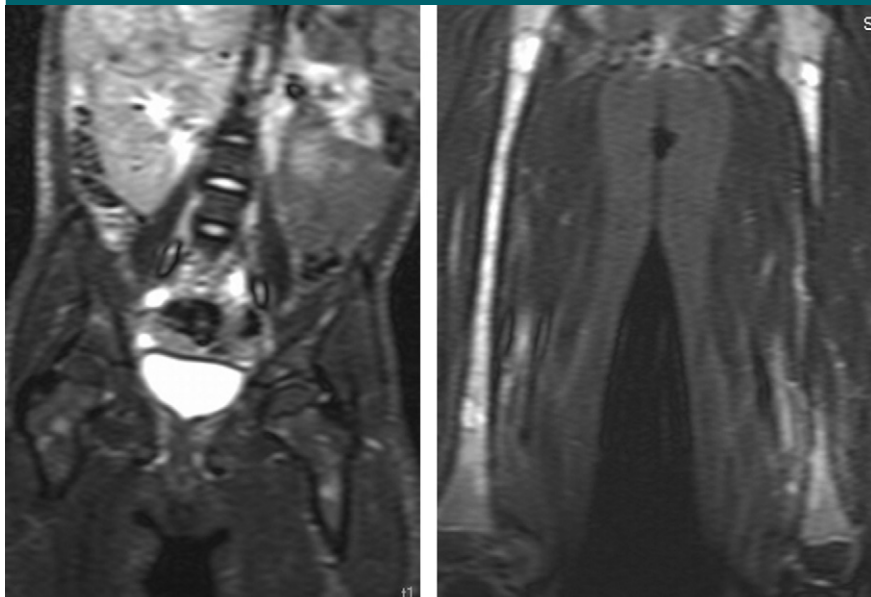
Coronal whole-body MR images show metastatic neuroblastomas. (a) Image in a 4-year-old girl with right adrenal primary tumor shows multiple foci of increased signal intensity in iliac bones and proximal femora. Skeletal and iodine 123 MIBG scintigraphy (not shown) results were negative in this patient. (b) Image in a 3-year-old boy with left adrenal primary tumor shows diffusely increased signal intensity in both femora. Skeletal and iodine 123 MIBG scintigraphy results (not shown) were positive in this patient.
